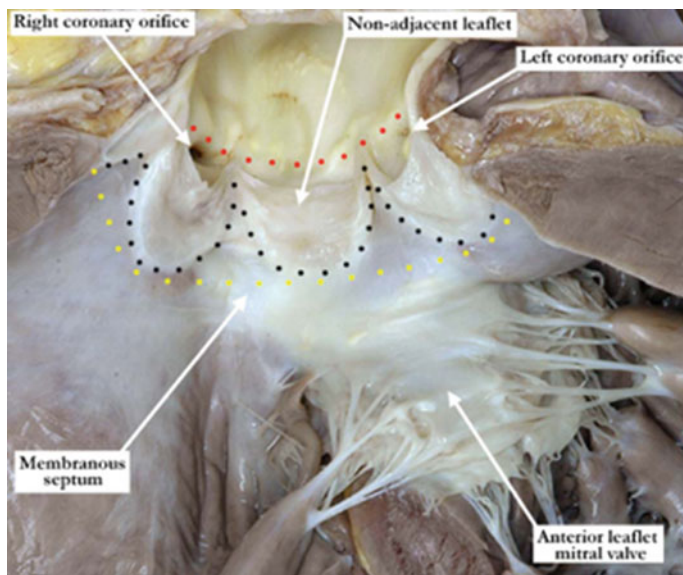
The opened aortic valve is supported by both muscle and fibrous tissue. The leaflets are marked by the black dots with the right coronary leaflet and the majority of the left coronary leaflet supported by muscle. Typically a portion of the left coronary leaflet and the entire non-coronary leaflet are supported by fibrous tissue or the area of aorta to mitral valve fibrous continuity. Note the membranous septum beneath the interleaflet triangle between the right and non-coronary leaflets. The semilunar leaflets attach at their most distal extent at the sinotubular junction (red dots). At the basal attachments of the valvar leaflets, the yellow dots mark the so-called echocardiographic ‘annulus’
